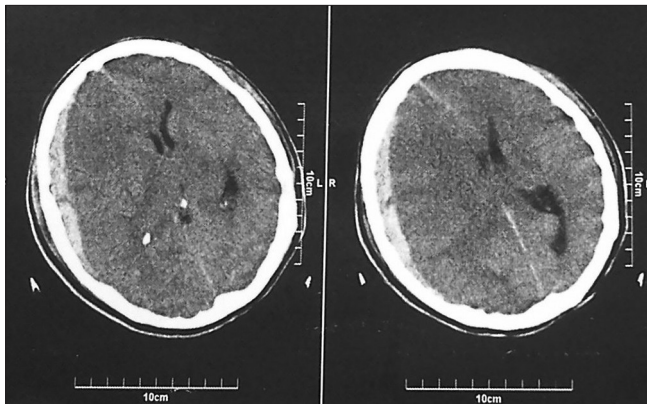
Brain computed tomography scan on admission demonstrates a high density hemispheric subdural hematoma on the right side with subarachnoid hemorrhage
